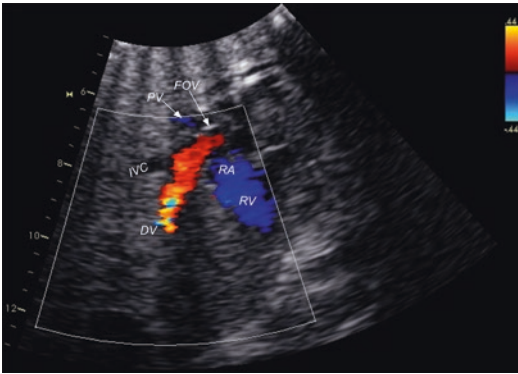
Posterior sagittal color Doppler imaging between the spine and the scapula provides excellent interrogation of the ductus venosus (DV) for a pulsed Doppler recording. For this technique, a well-tuned sector transducer tends to be more successful than a broad linear or curved transducer, particularly when it comes to a perfect alignment of the pulsed Doppler beam. *FOV* foramen ovale valve, *IVC* inferior vena cava, *PV* pulmonary vein, *RA* right atrium, *RV* right ventricle
